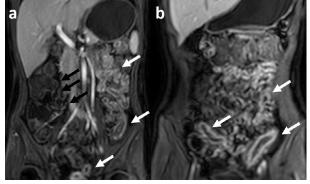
A 14-year-old girl with known Crohn's disease. Coronal contrast-enhanced T1-weighted with fat suppression images show skip lesions. Wall thickening in the rectum, sigmoid colon, terminal ileum, and jejunal loops (white arrows) are shown. In figure (a), black arrows show normal bowel wall thickness
